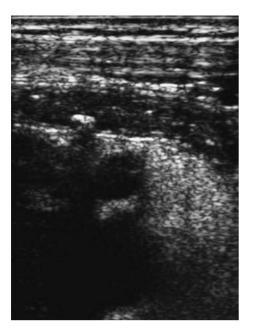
Acute appendicitis in a 14-year-old boy showing the presence of an appendicolith with posterior acoustic shadowing on ultrasound
